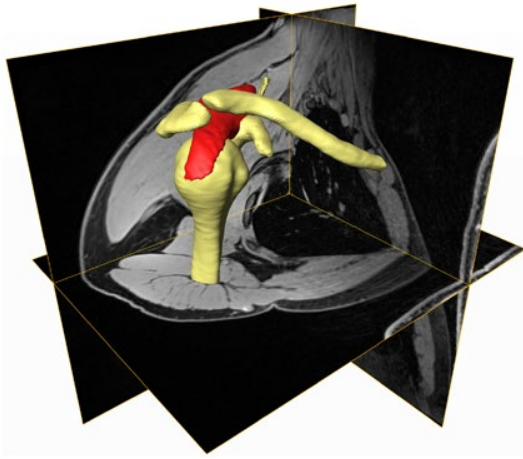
Reconstruction of the clavicle, scapula, humerus and supraspinatus tendon from MRI. The bones are shown in yellow and the supraspinatus muscle-tendon unit in red. Three MRI slices are shown as reference.
